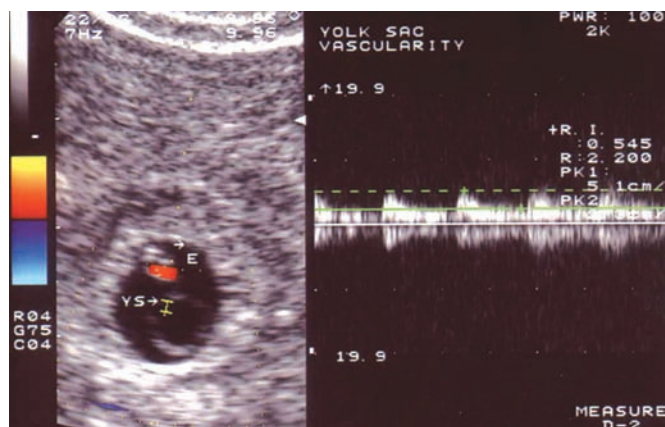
The transvaginal scan of a 9 weeks' gestation, complicated by bleeding. The pulsed Doppler waveform analysis indicates continuous blood flow. A few days after examination was completed spontaneous abortion occurred.
